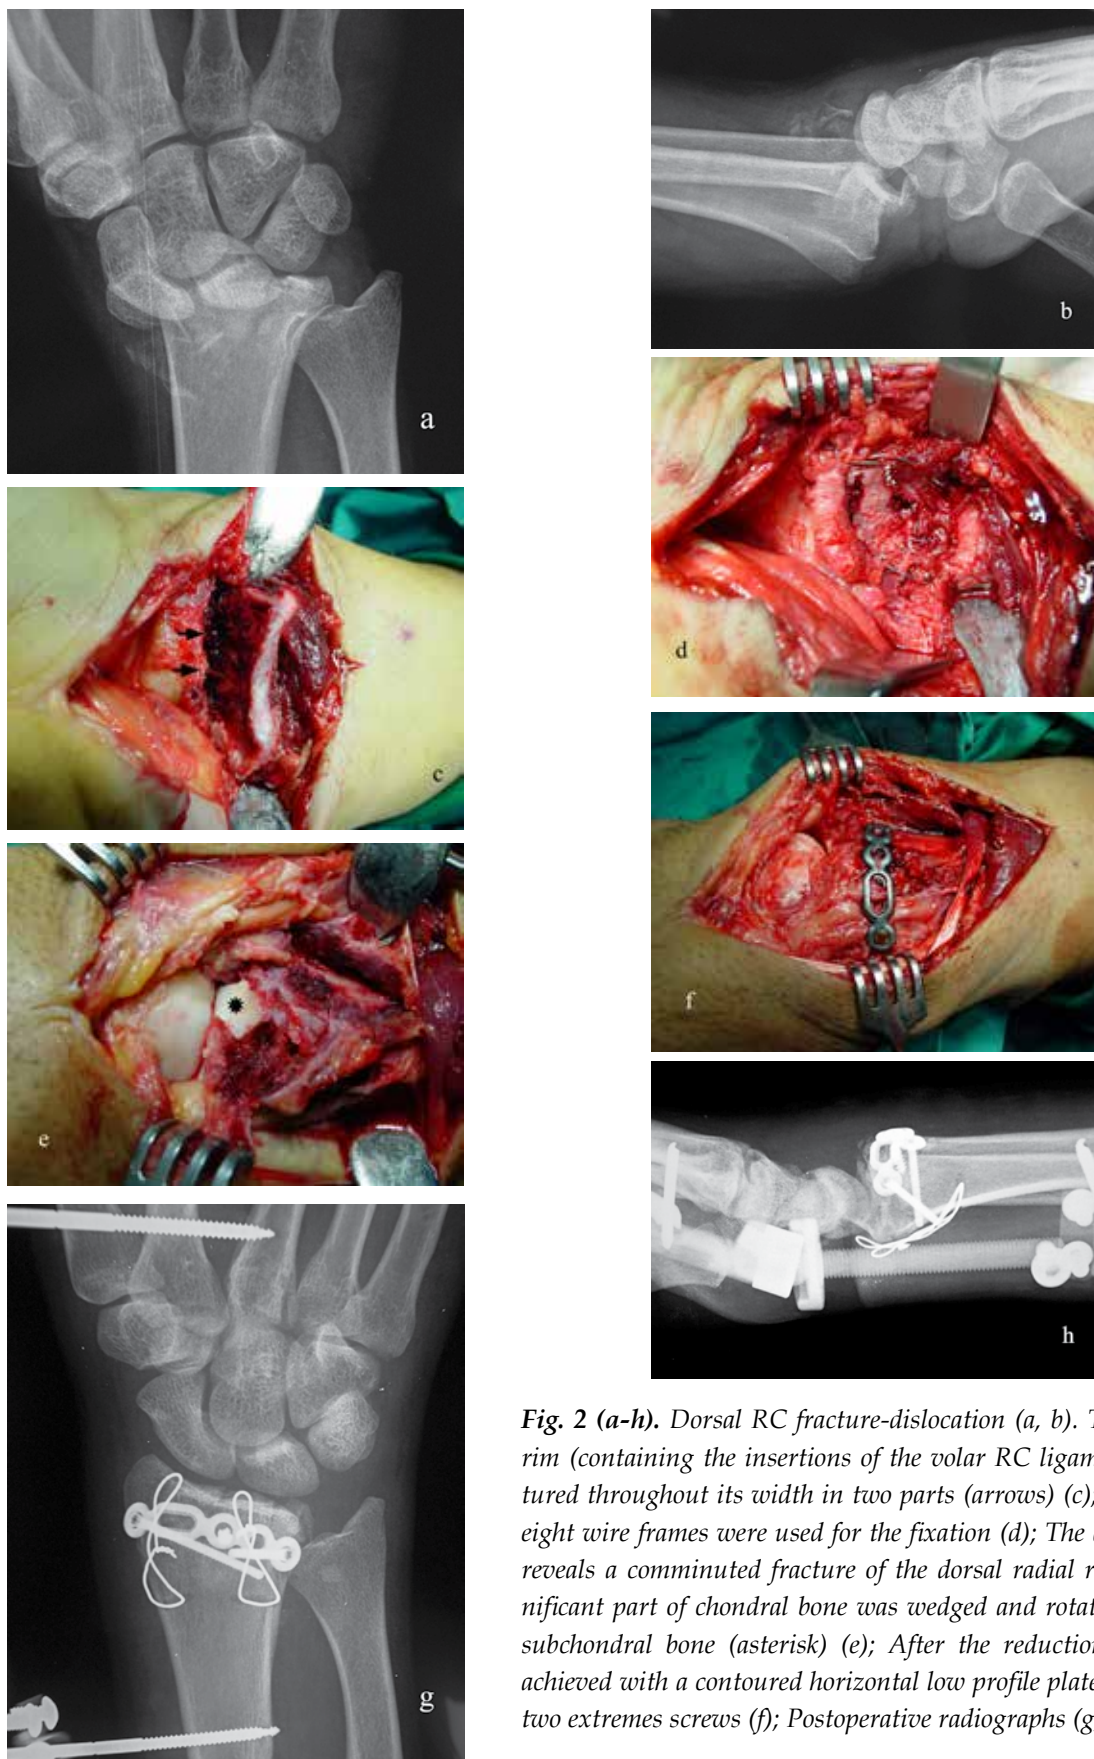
(a-h). Dorsal RC fracture-dislocation (a, b). The volar radial rim (containing the insertions of the volar RC ligaments) was fractured throughout its width in two parts (arrows) (c); Two figures of eight wire frames were used for the fixation (d); The dorsal approach reveals a comminuted fracture of the dorsal radial rim while a significant part of chondral bone was wedged and rotated 90o into the subchondral bone (asterisk) (e); After the reduction, fixation was achieved with a contoured horizontal low profile plate using only the two extremes screws (f); Postoperative radiographs (g, h).
